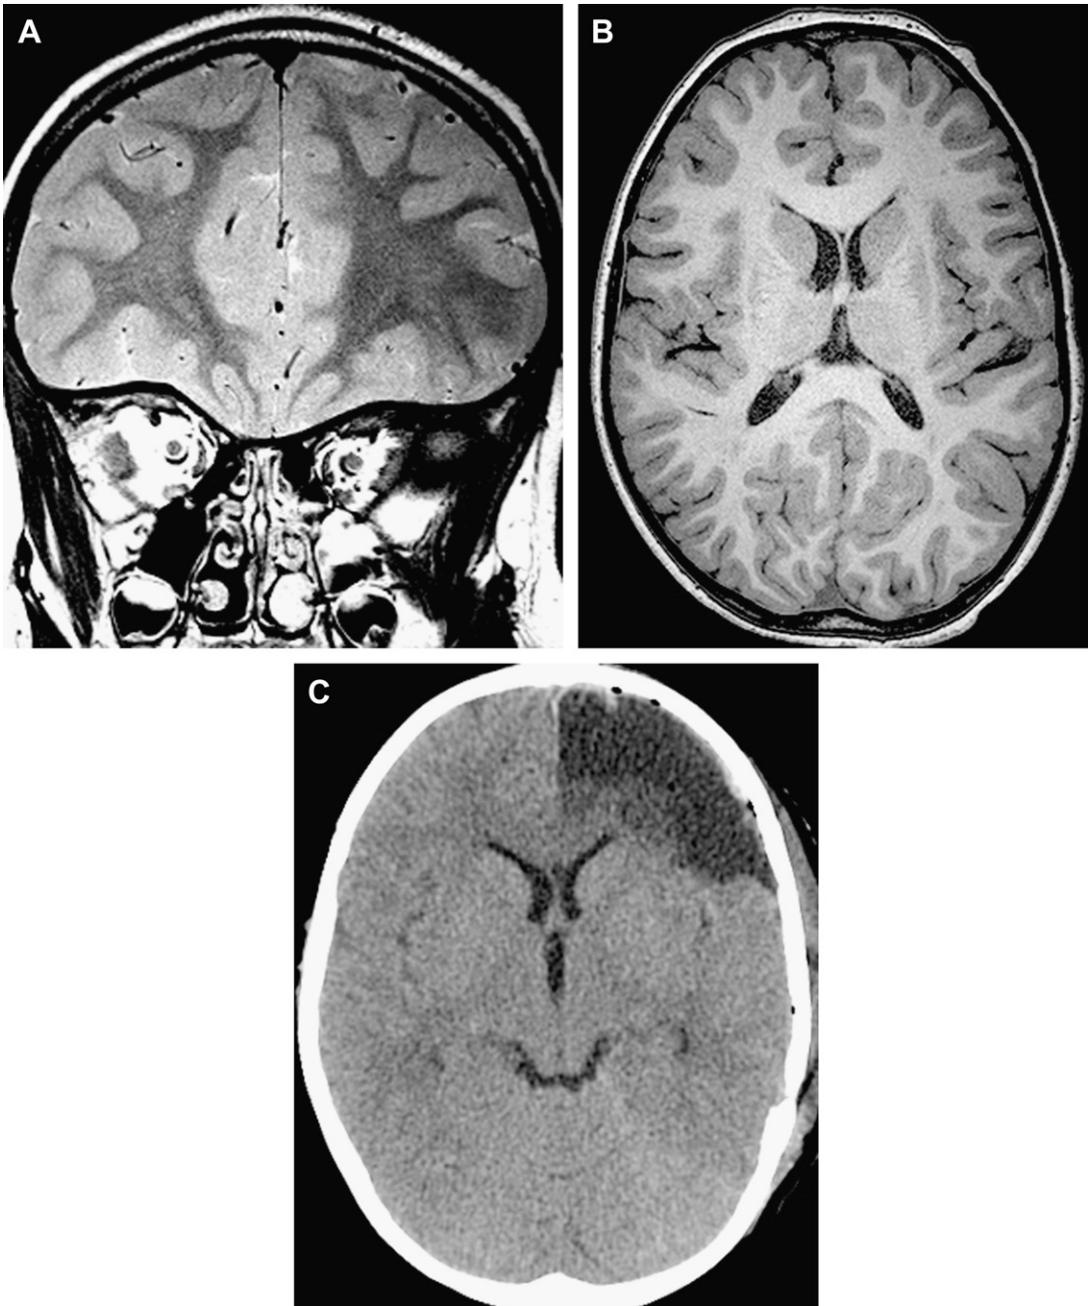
FCD I, normal appearance. (A) Coronal PD. No abnormality was found in this patient who presents with a left frontal seizure focus. (B) Axial high-definition T1. No abnormality is found here either. (C) Postsurgical CT. The patient was operated on according to the MEG abnormalities, with large anterior frontal lobectomy. Pathology demonstrated diffuse abnormalities consistent with FCD I.
